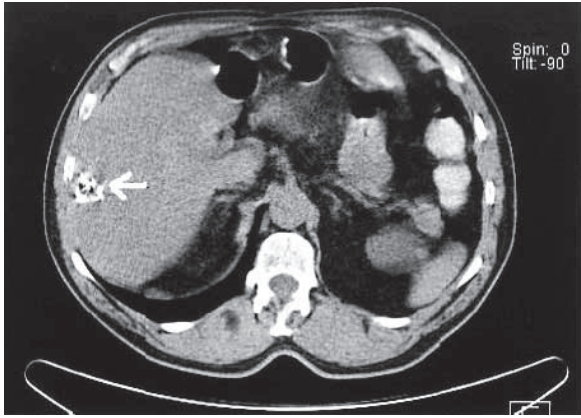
Abdomen CT image showing a contrast absorbed lesion in the right liver lobe at the site of a removed liver metastasis.
